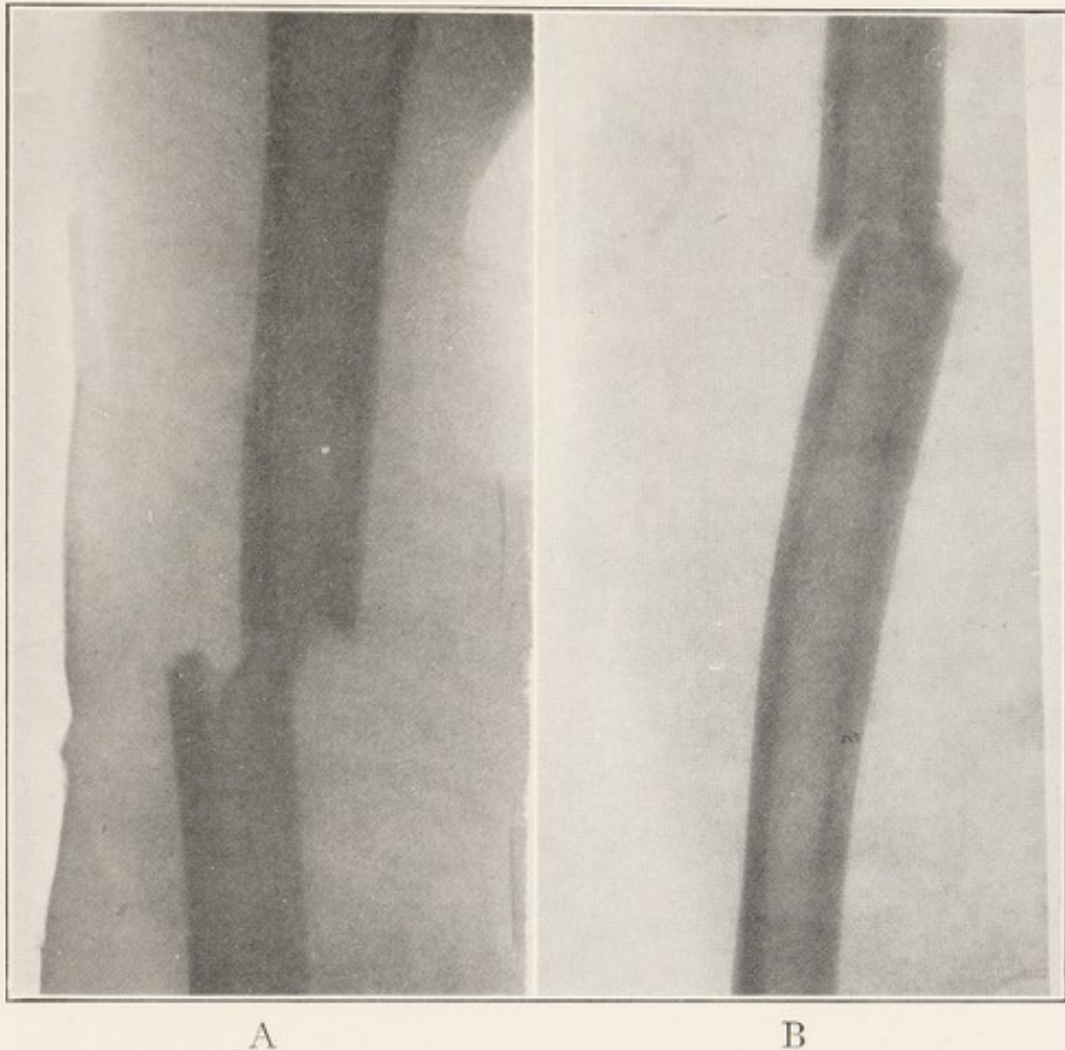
X-RAY SHOWING FRACTURE OF MIDDLE THIRD OF HUMERUS, ANTEROPOSTERIOR VIEW.
